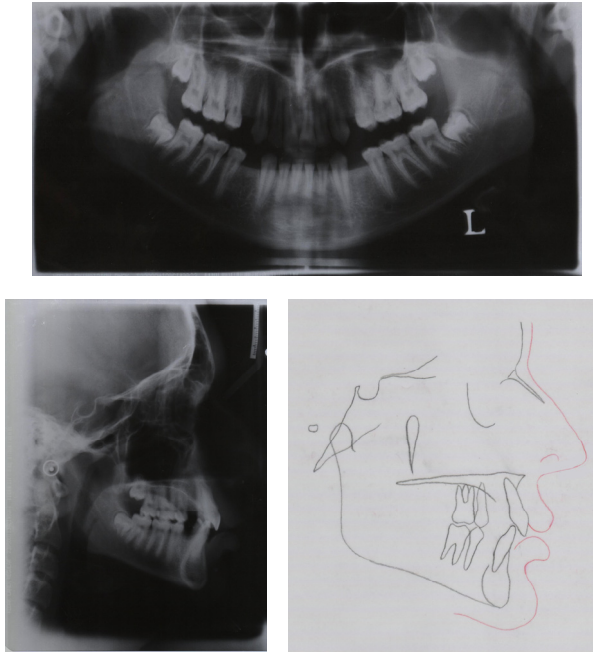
Figs 3-a to 3-c, pretreatment lateral cephalograms, cephalometric tracing and panoramic radiograph.
